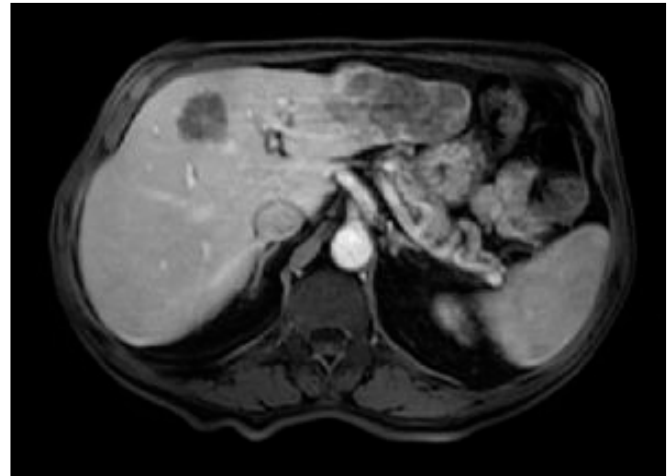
Gd-EOB enhanced MRI at hepatobiliary phase showing two hypointense lesions ((Score 3 metastases) on segments IV and II
